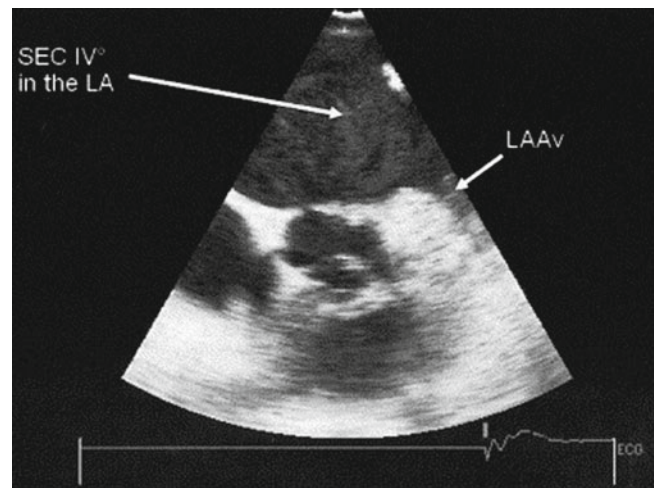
Transesophageal echocardiography with dense spontaneous echo contrast (SEC). LA left atrium, LAAv left atrial appendage peak emptying velocity (Reprinted with Permission Bernhardt et al. [59])
